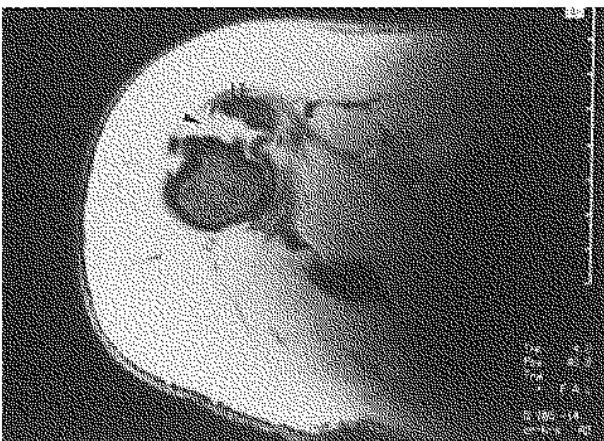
MRI demonstrating the fibrous tissue between the proximal humerus and the lesser tubercle (L.T.).
